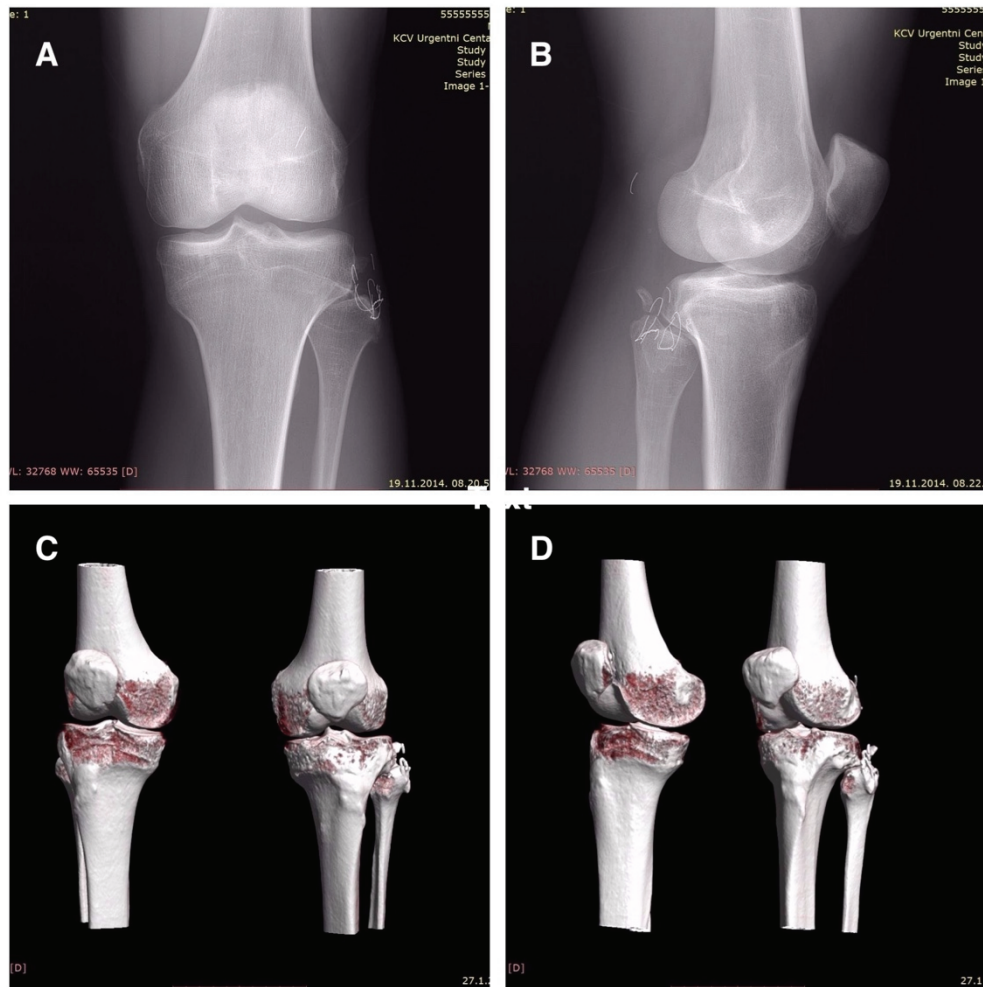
Postoperative radiography (X ray) and computed tomography (CT) findings:
